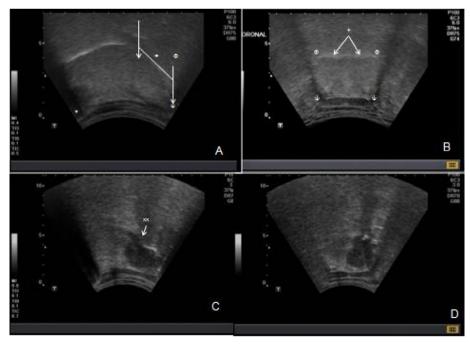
Transcervical ultrasound examination of oropharynx. Parasagittal view (A) demonstrates intact hyperechoic oral mucosa of oral and base of tongue (+). The hyoid (ψ) and mandibular (*) shadows are shown. The sonographic base of tongue is the posterior one third of the distance between the central portions of the mandible and hyoid annotated by (\downarrow). The palatine tonsillar region is isoechoic (Φ). On coronal view (B) hyoid shadows are seen bilaterally (ψ). The oral mucosa is intact (+). The base of tongue musculature is noted to be symmetric. Panels C and D are images representative of a base of tongue lesion. On parasagittal view is a hypoechoic lesion, the majority of which is beneath the mucosal surface of the base of tongue, with a slight disruption of the mucosa (xx). The mass is also visualized in coronal view (D). Extent across midline is appreciated in coronal view.
